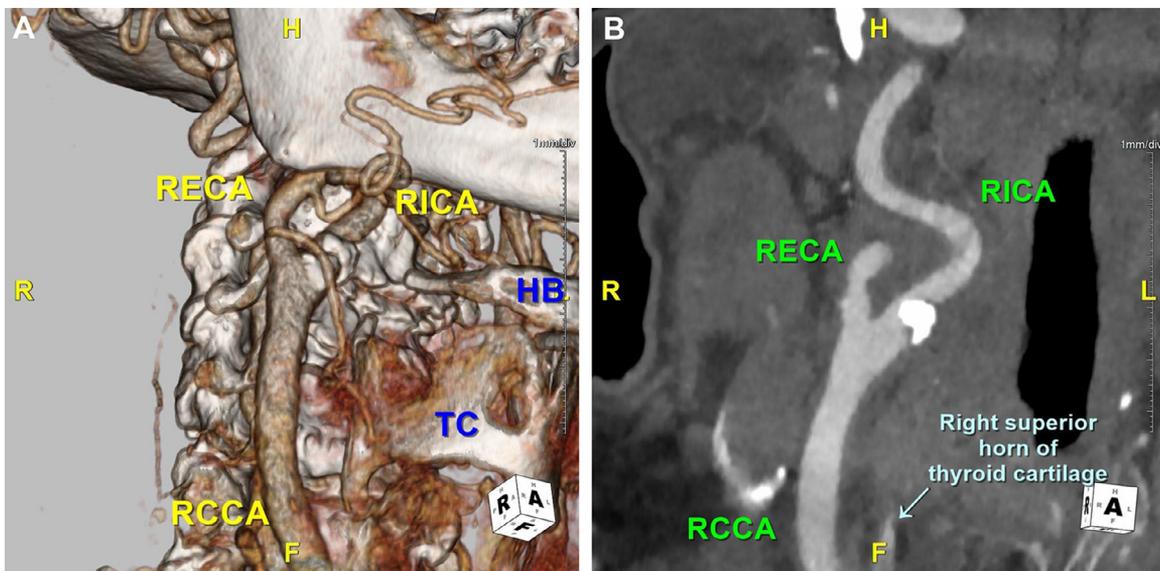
Postoperative three-dimensional computed tomography angiography (3D-CTA) of the cervical arteries (A) and multiplanar reconstruction image of the 3D-CTA (B). HB, hyoid bone; RCCA, right common carotid artery; RECA, right external carotid artery; TC: thyroid cartilage.
